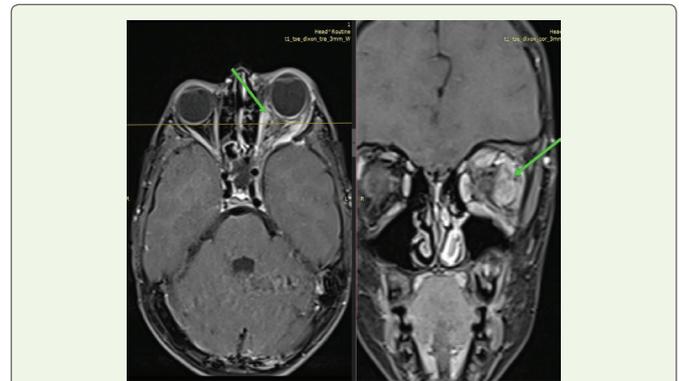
MRI orbit, axial and coronal post-contrast fat-suppressed T1-weighted image shows enhancing enlargement of the left medial and lateral rectus muscles (arrows) with mild surrounding orbital fat stranding, suggestive of extraocular muscle neurofibroma in the background of neurofibromatosis type 1.
